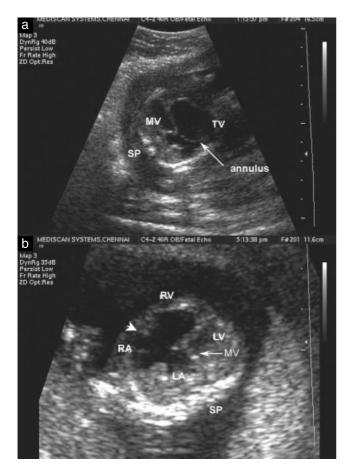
Ultrasound images of: (a) apical four-chamber view of the heart showing grossly dilated right ventricle with thin myocardium; (b) right ventricle (RV) with thin myocardium and absence of valve during systole (arrowhead indicates atrioventricular junction; mitral valve (MV) seen in closed position (arrow)). LA, left atrium; LV, left ventricle; RA, right atrium; SP, spine; TV, tricuspid valve.
